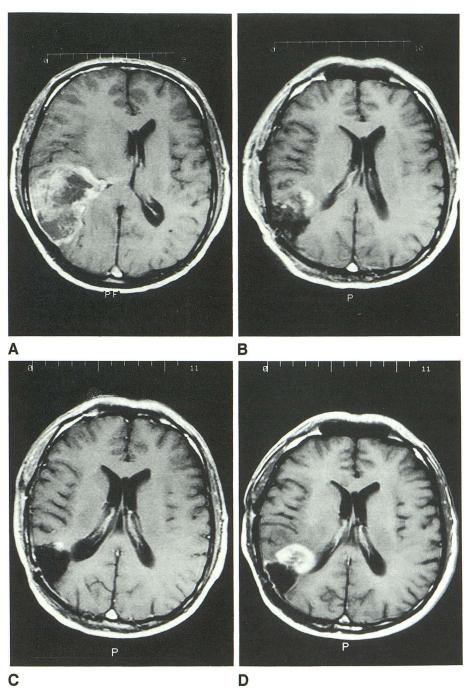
Axial T1-weighted MR image (600/20/2) obtained preoperatively (A), on the first day (B), 4 months (C), and 10 months (D) after extirpation of glioblastoma.
